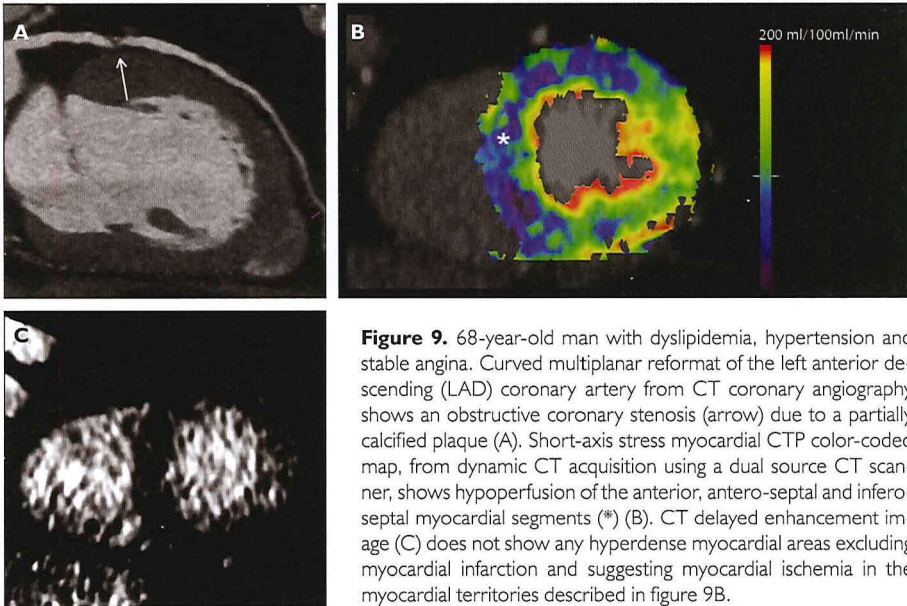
68-year-old man with dyslipidemia, hypertension and stable angina. Curved multiplanar reformat of the left anterior descending (LAD) coronary artery from CT coronary angiography shows an obstructive coronary stenosis (arrow) due to a partially calcified plaque (A). Short-axis stress myocardial CTP color-coded map, from dynamic CT acquisition using a dual source CT scanner, shows hypoperfusion of the anterior, antero-septal and infero-septal myocardial segments (*) (B). CT delayed enhancement image (C) does not show any hyperdense myocardial areas excluding myocardial infarction and suggesting myocardial ischemia in the myocardial territories described in figure 9B.
